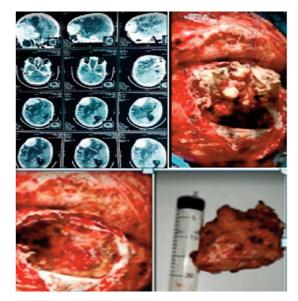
Head CT showing right fronto-temporal (meningioma) tumor (A) with enhancement after injection, surrounded by severe perilesional edema; bone involvement and skin infiltration. Intraoperative image (B, C) supine patient,forehead at the zenith. Aspect of the tumor after excision (D).
